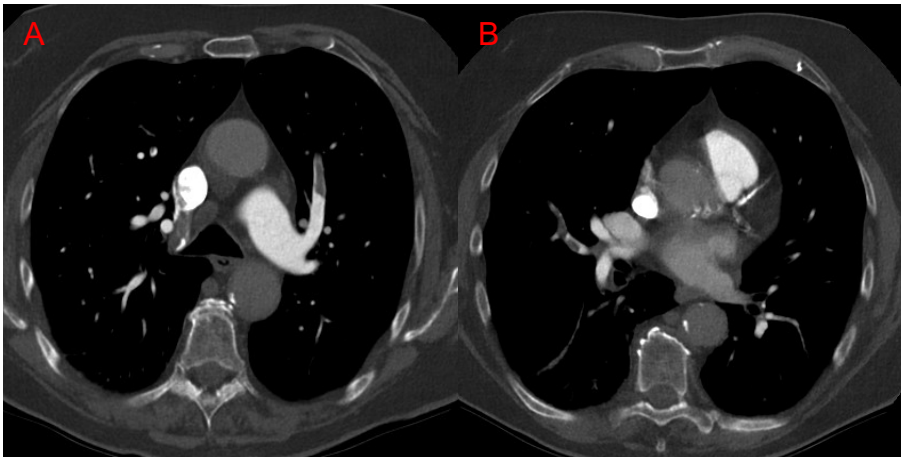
CASE 4: AXIAL CT OF CTPA OF COPD PATIENT
